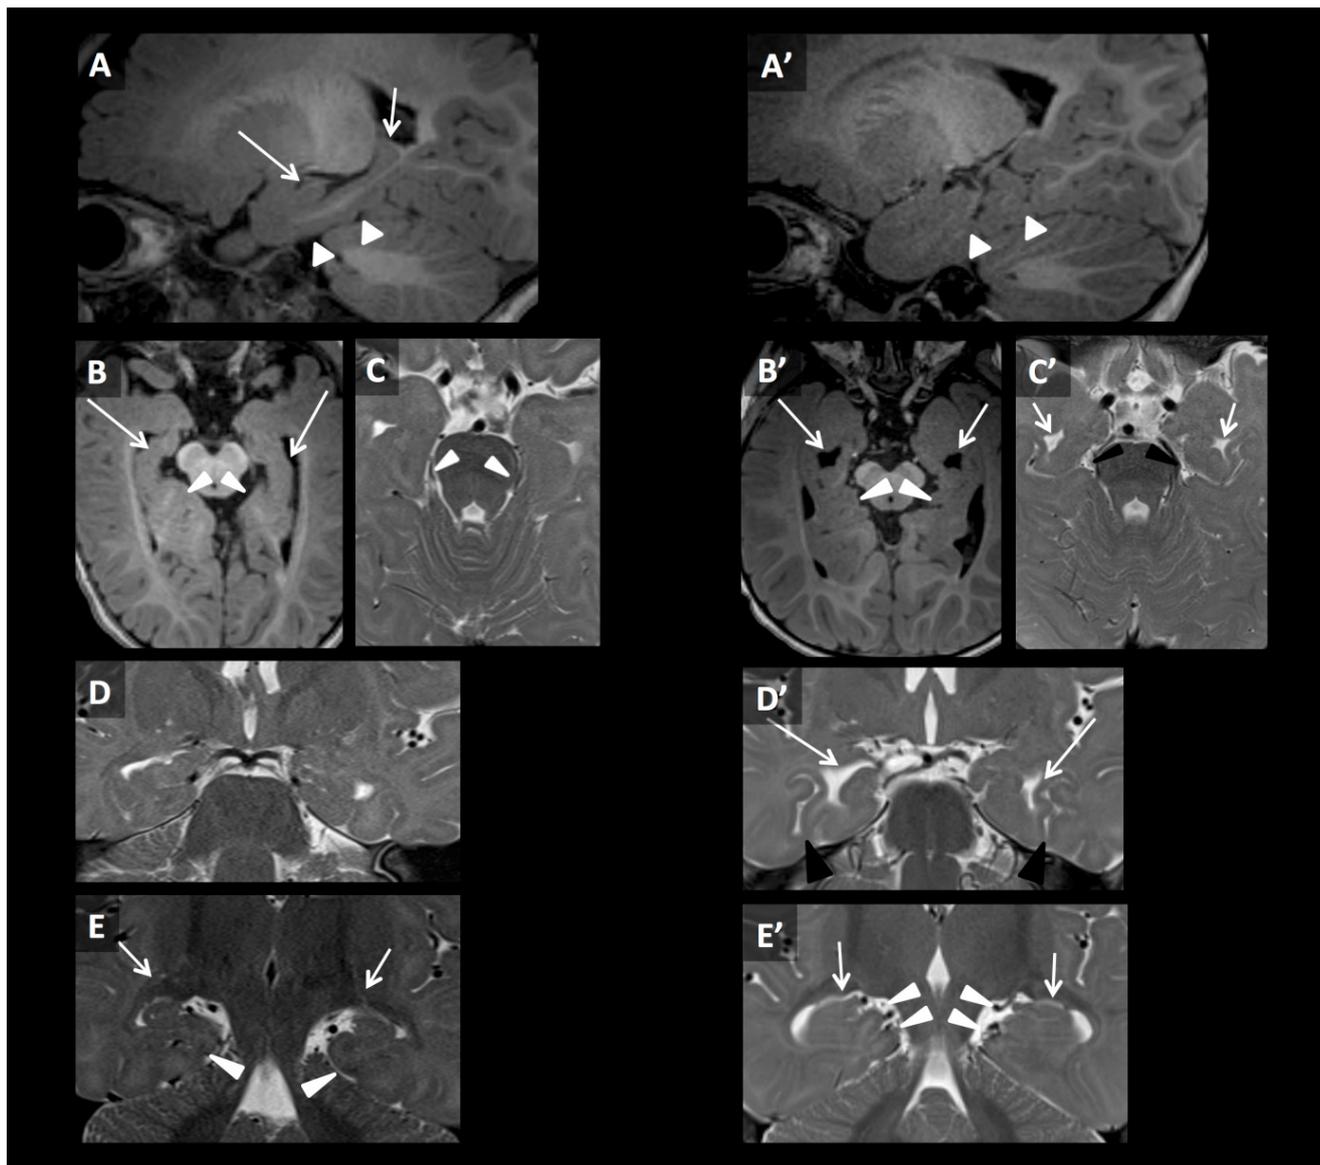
Normal MRI (left) and bilateral temporal lobe dysplasia (right)
